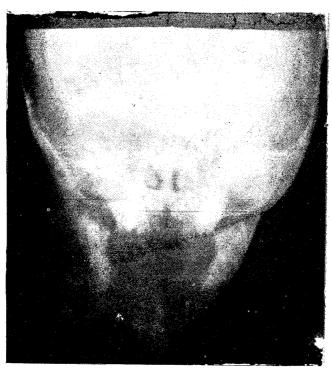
X-ray showing wide seperation of the two components of the mandible.
